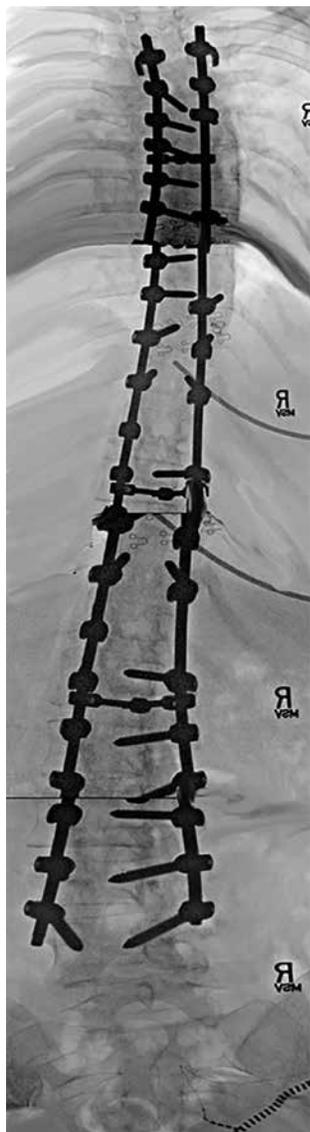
A compiled anteroposterior (AP) radiograph demonstrating the patient's Harrington rod surgical fusion extending from T1-L4. Four individual AP radiographs were cropped and resized to produce this image.
